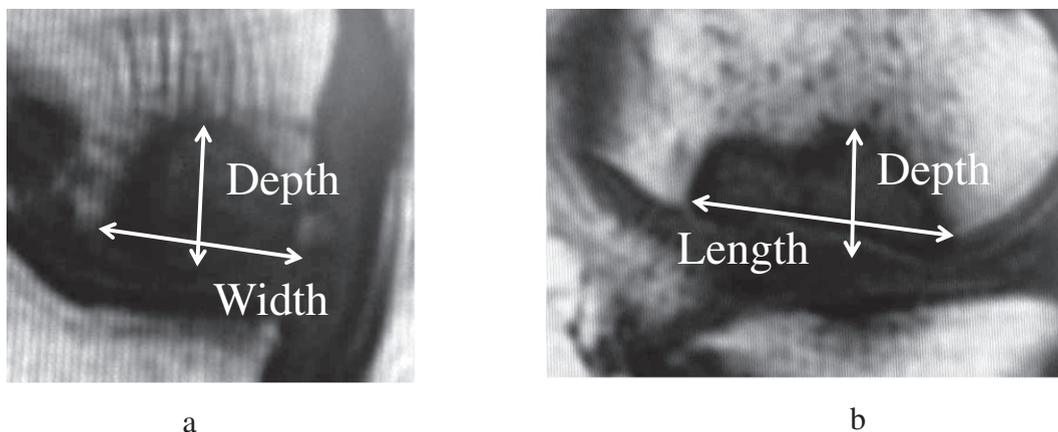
MRI T1 Weighted Image a) Coronal Plane, b) Sagittal Plane
